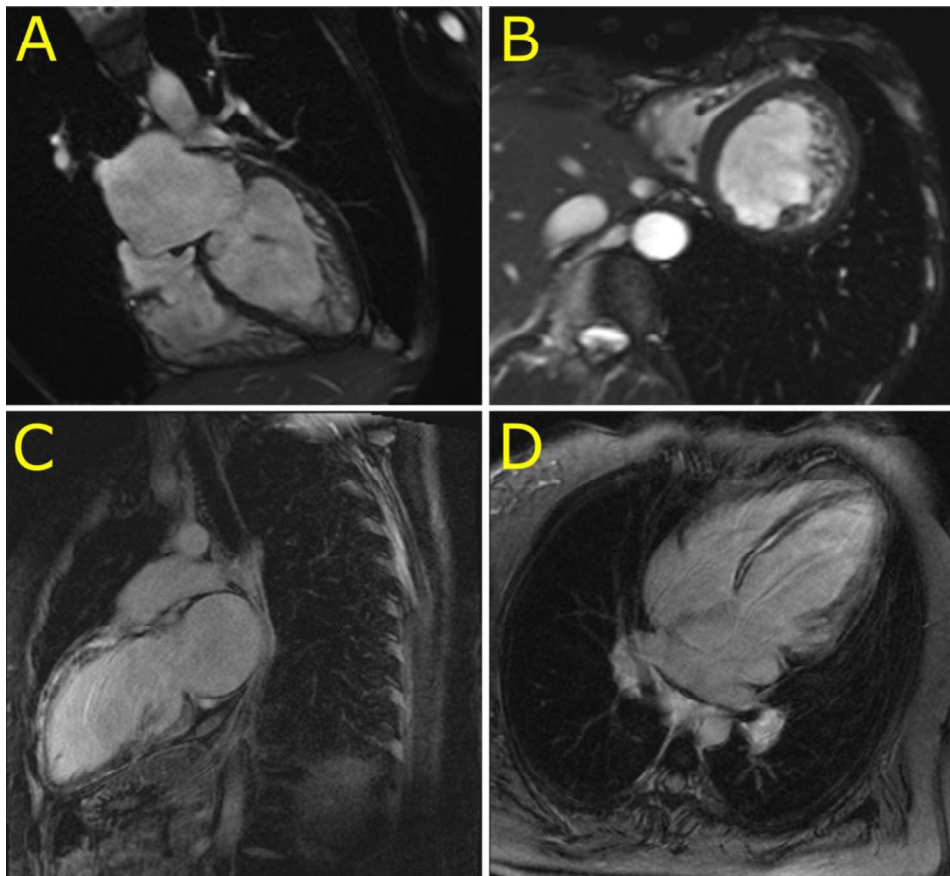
Cardiovascular magnetic resonance imaging in patients with left ventricular non-compaction cardiomyopathy (P4) and dilated cardiomyopathy with an extensive late gadolinium enhancement (P2). (A,B): Four chamber and short axis views of left ventricular non-compaction cardiomyopathy in P4. (C,D): Two chamber long axis and four chamber views of an extensive late gadolinium enhancement in the ventricular septum and left ventricular anterior wall mimicking inflammatory cardiomyopathy in P2.
